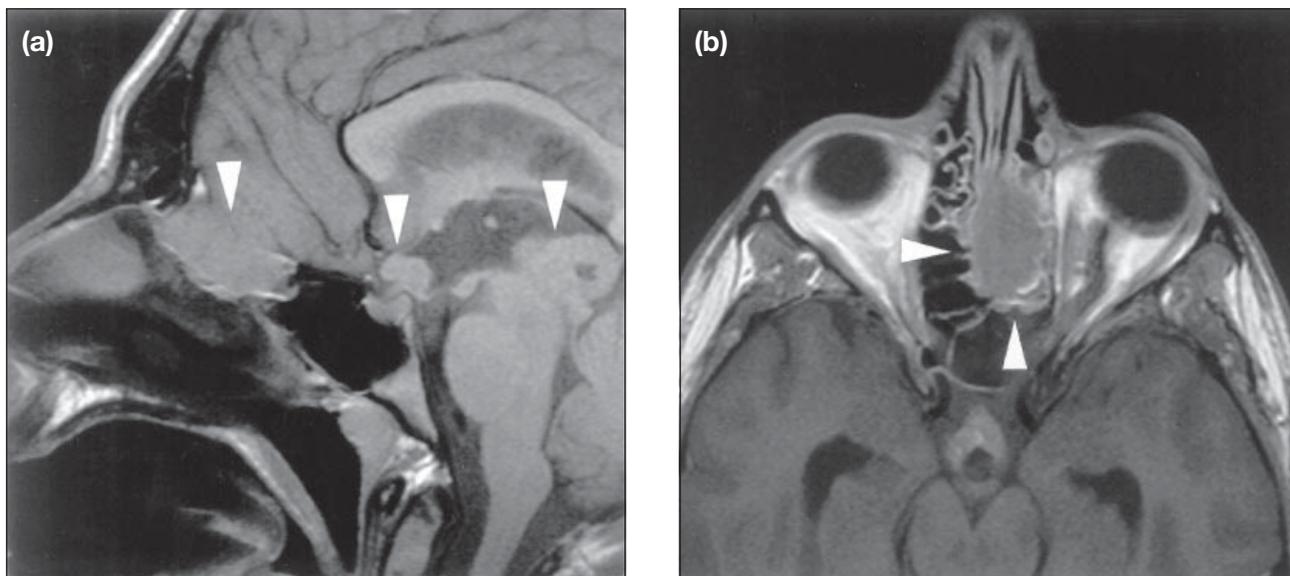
(a) Sagittal T1-weighted magnetic resonance imaging of the head demonstrates tumour growth of the pineal gland with spread to the suprasellar region and upper nasal cavity (arrowheads) and (b) axial T1-weighted magnetic resonance imaging of the head shows tumour infiltration into the left nasal cavity (arrowheads).
